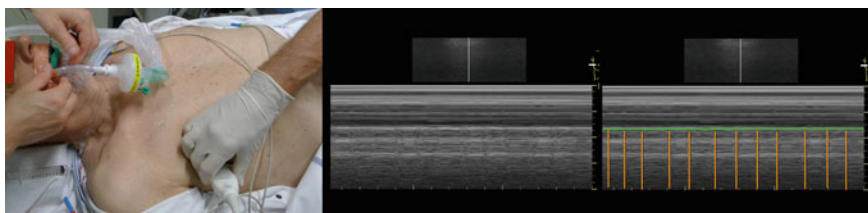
Lung Pulse. *Left* The ultrasound probe is placed transversely in an inter-space between two ribs during normal ventilation. *Middle* The scanning image, *upper* B-mode scan, *lower* M-(Motion-)mode. *Right* In the non-ventilated, but inflated, lung the heart will make the two pleural layers (*green*) move a bit with every heartbeat, creating the artifact known as “lung pulse” (*orange*)
